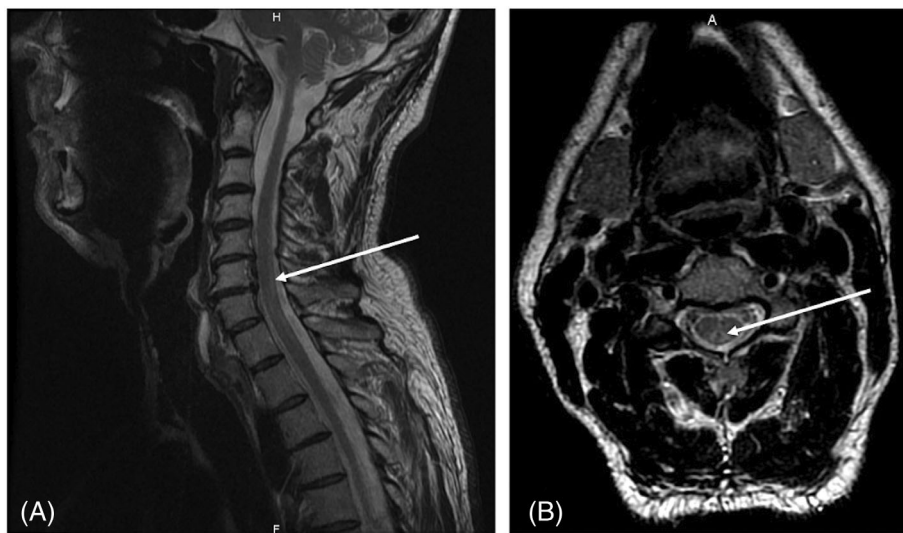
Sagittal (A) and axial (B) MRI section of a patient with copper deficiency showing an hypersignal in FLAIR sequence corresponding to a posterior column syndrome.
